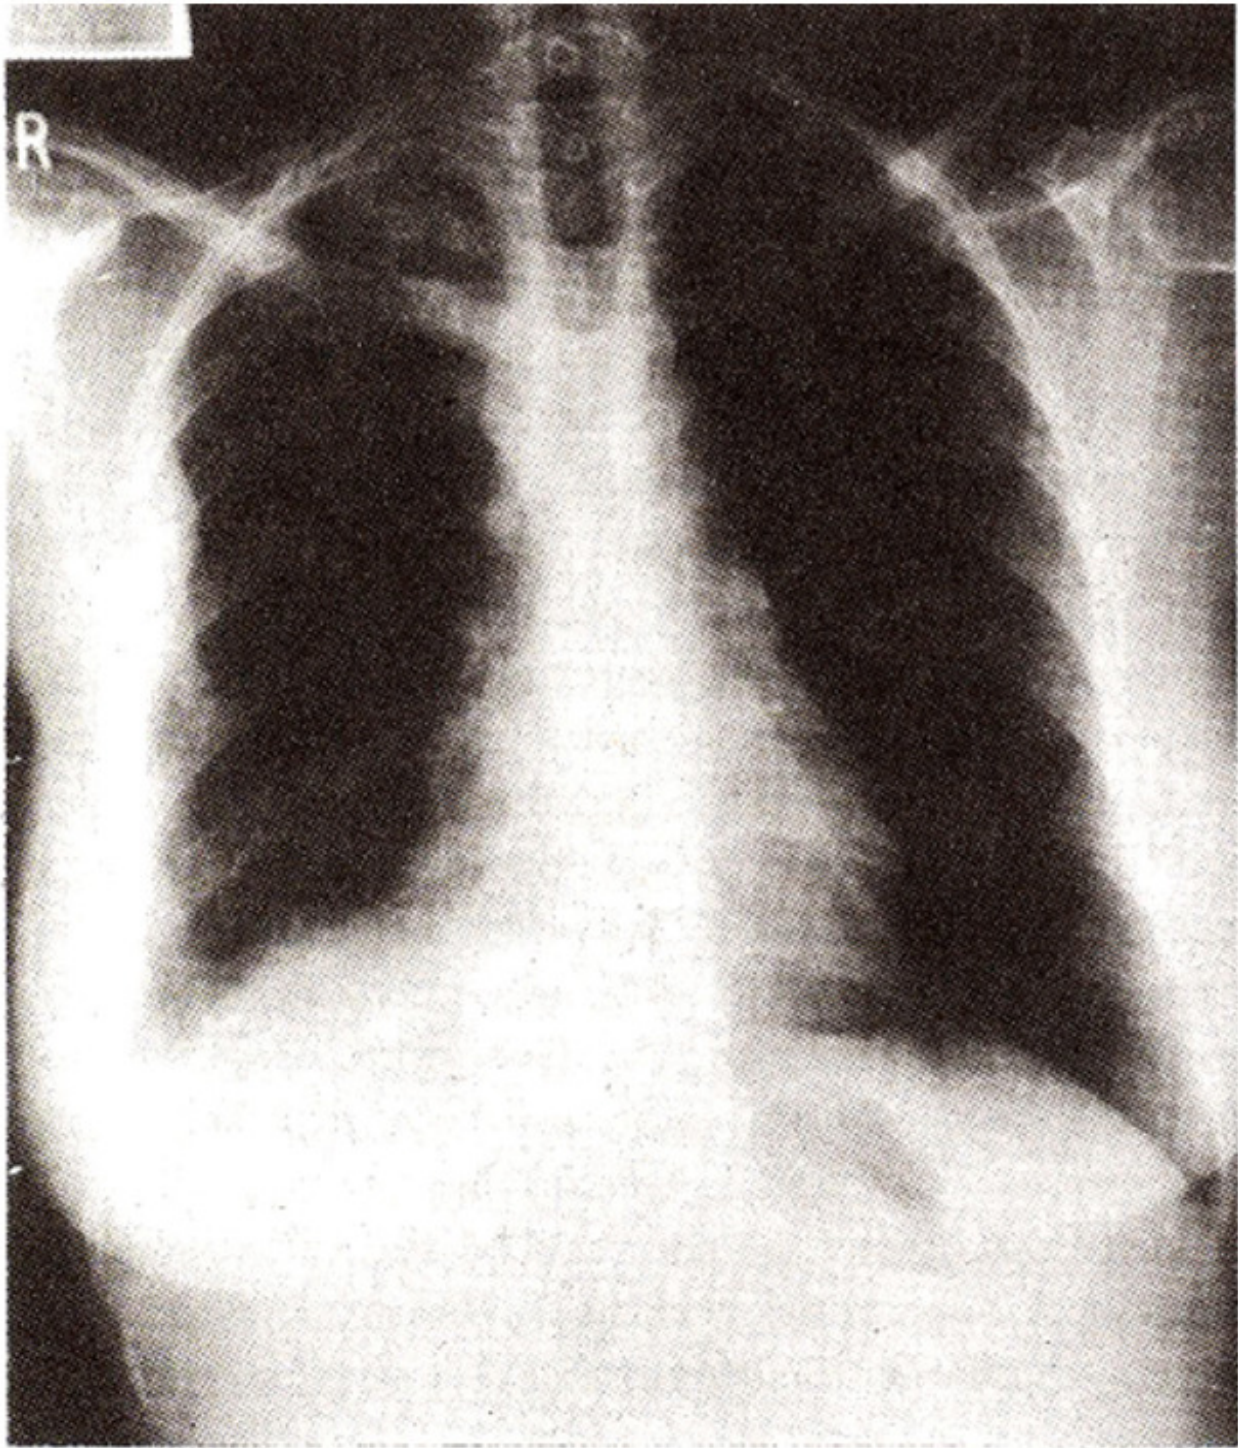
Postero-anterior radiograph of chest showing a soft tissue mass in relation to the eroded right fourth rib.
